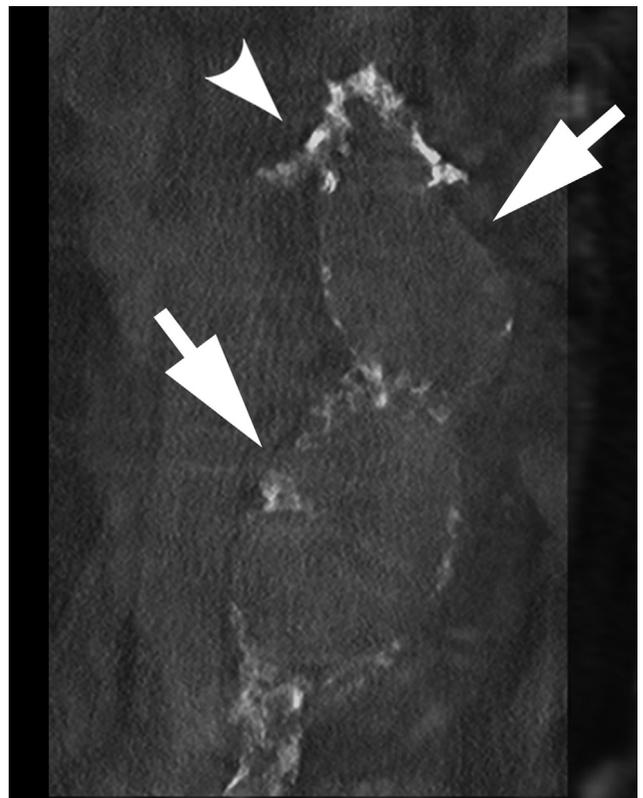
Coronal view of cone-beam CT image in patient 1. Landmarks such as aortic wall (arrows) or target vessels calcifications such as the right renal artery (arrowhead) were used for coregistration.
